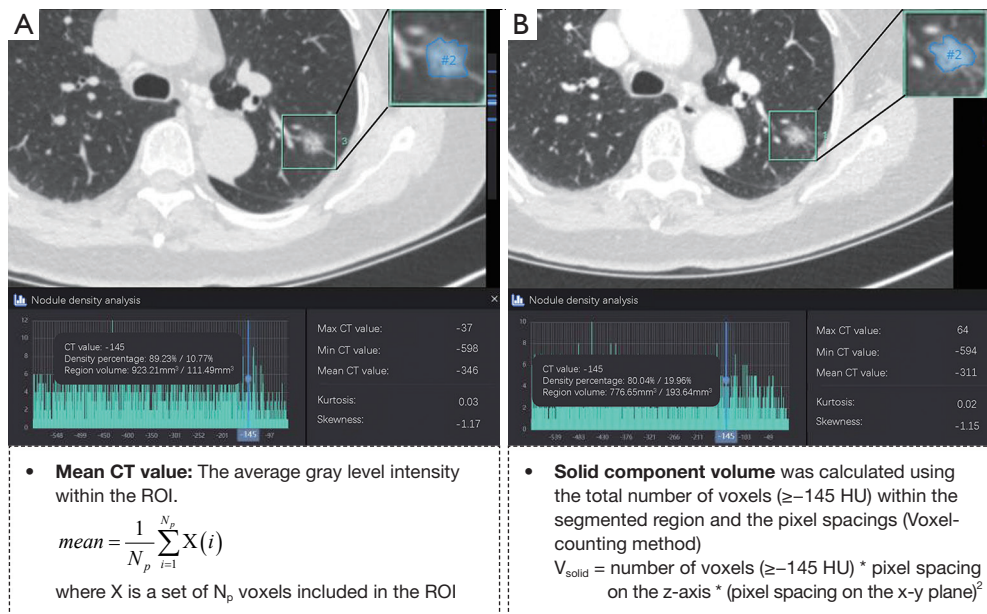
Radiologic findings of GGNs from CT images. (A) Nonenhanced CT images. (B) Enhanced CT images. The relevant quantitative parameters were calculated based on automatic accurate segmentation of the detected nodules (displayed in the upper right corner), including maximum CT value, minimum CT value, mean CT value, nonsolid component volume, solid component volume, kurtosis, and skewness. The formulae for calculating the mean CT value and solid component volume are also provided. GGN, ground-glass nodule; CT, computed tomography; ROI, region of interest.
